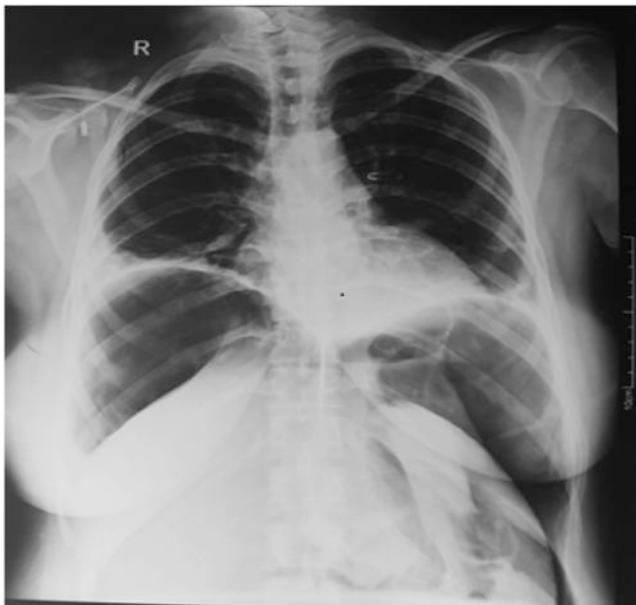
Chest x-ray PA view
